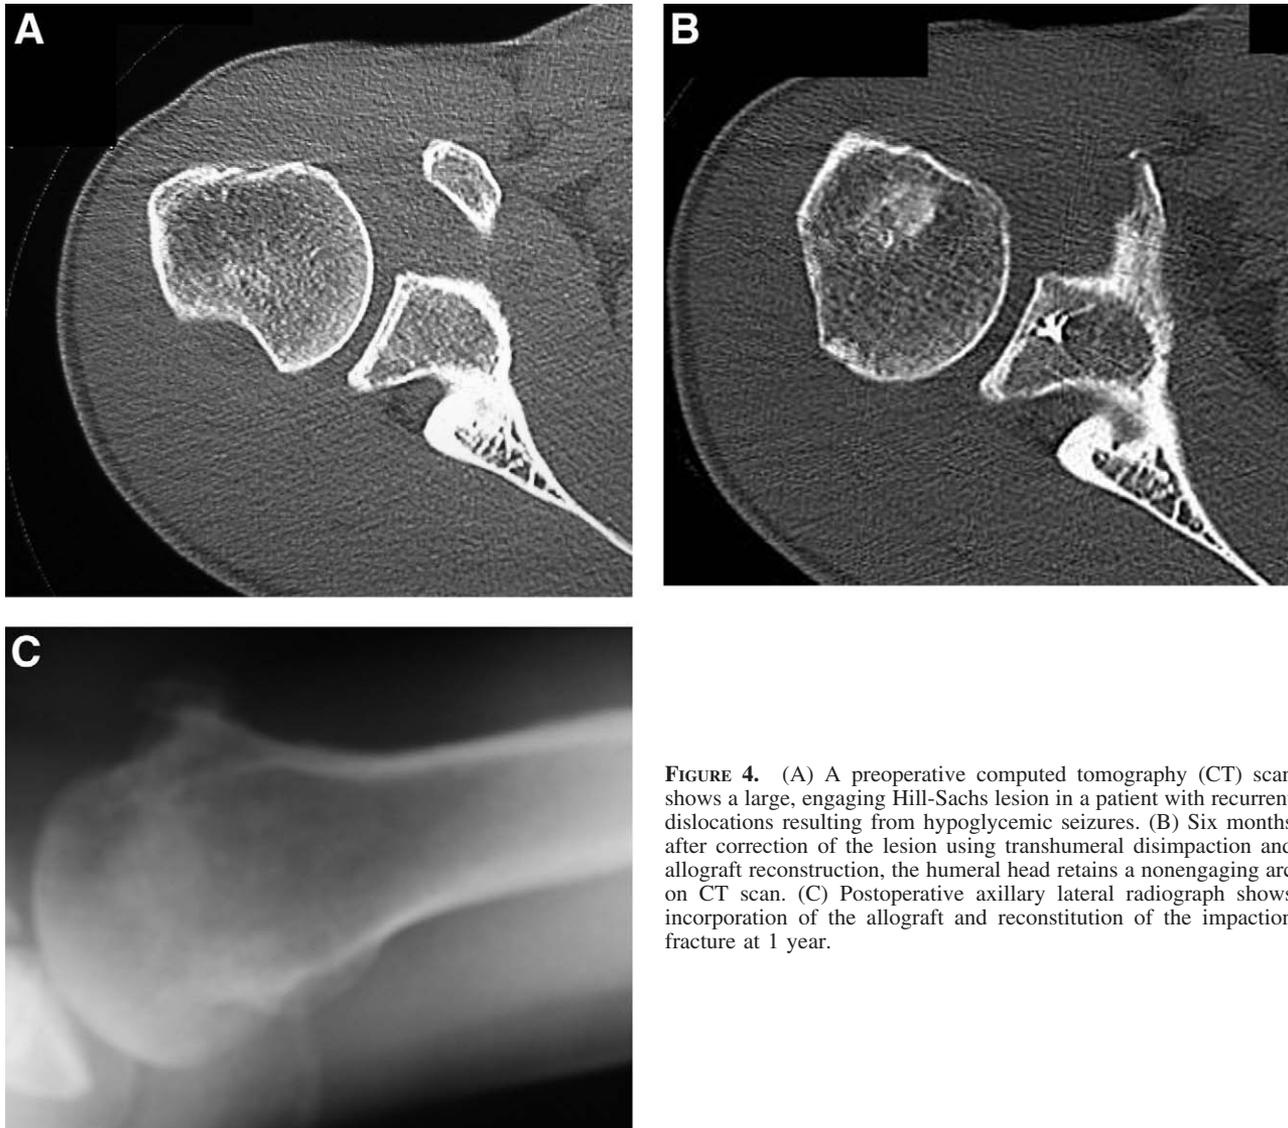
(A) A preoperative computed tomography (CT) scan shows a large, engaging Hill-Sachs lesion in a patient with recurrent dislocations resulting from hypoglycemic seizures. (B) Six months after correction of the lesion using transhumeral disimpaction and allograft reconstruction, the humeral head retains a nonengaging arc on CT scan. (C) Postoperative axillary lateral radiograph shows incorporation of the allograft and reconstitution of the impaction fracture at 1 year.
